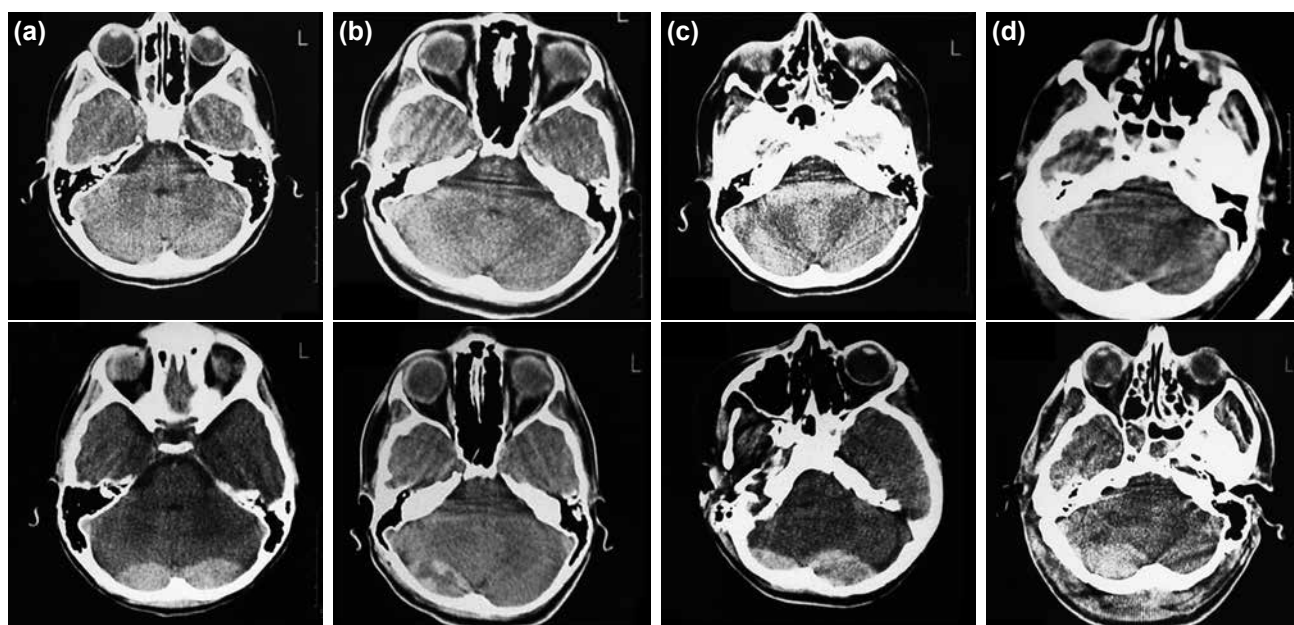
(a) Case 1: S.K., 9 years old, initial computed tomography (CT) view (above) and view after 24 hours (below). (b) Case 2: Ş.S., 13 years old, initial CT view (above) and view after 10 hours (below). (c) Case 3: S.Y.; 10 years old, initial CT view (above) and view after 12 hours (below). (d) Case 4: T.Ş., 33 years old, initial CT view (above) and view after 12 hours (below).
